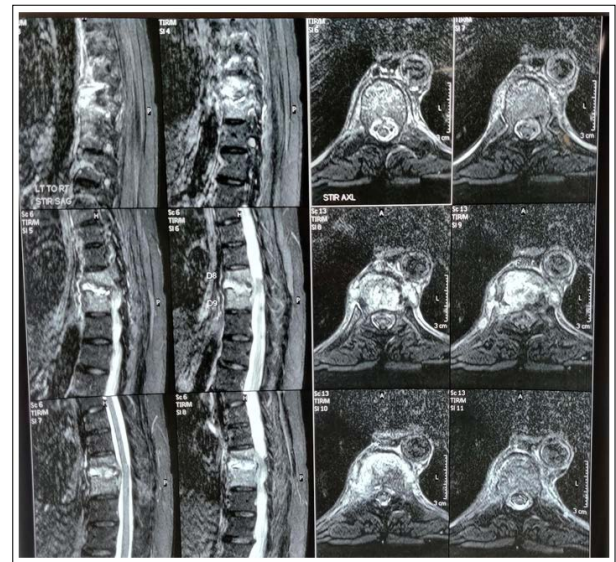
MRI Imaging Showing Tuberculosis of the Spine at D8-D9
